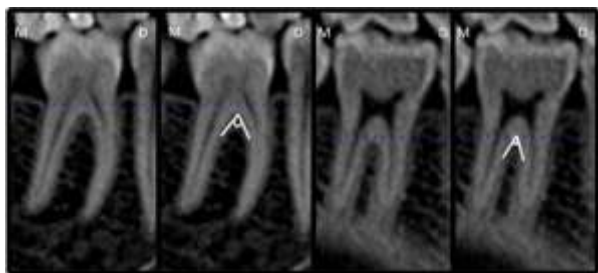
Angle of roots was measured sagittal CB-CT images at selected mandibular first molar teeth. Angle of roots is the angle between the line drawn from the highest crown point of the furcation entrance to the furthest mesial curvature point of the mesial root and the line drawn at the highest crown point of the furcation entrance to the furthest mesial curvature point of the mesial root at a sagittal CB-CT images view where the angle of roots mesial and the distal root is the widest. M, Mesial; D, Distal.
